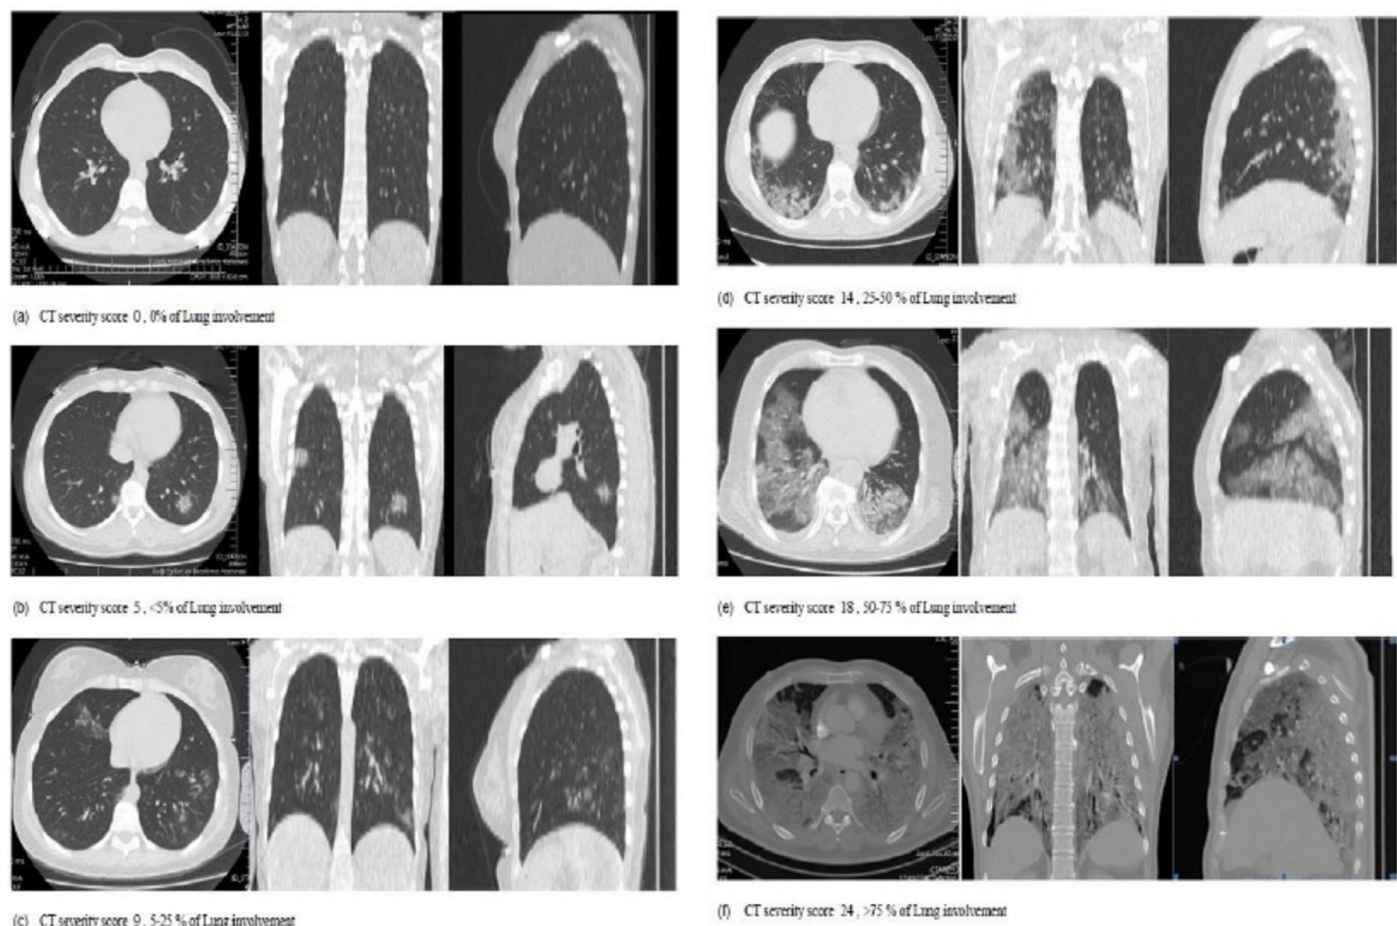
Different CT severity score of Lung involvement in COVID-19 pneumonia on axial, coronal, and sagittal images. 0% of Lung lobe involvement (a); < 5% of Lung involvement CTSS:5 (b); 5-25% of Lung involvement CTSS:9 (c); 25-50% of Lung involvement CTSS:14 (d); 50-75% of Lung involvement CTSS:18 (e); > 75% of RLL involvement CTSS:24 (f) High Ddimer value (3307) CT severity score:19 , 50-75 % of Lung involvement
